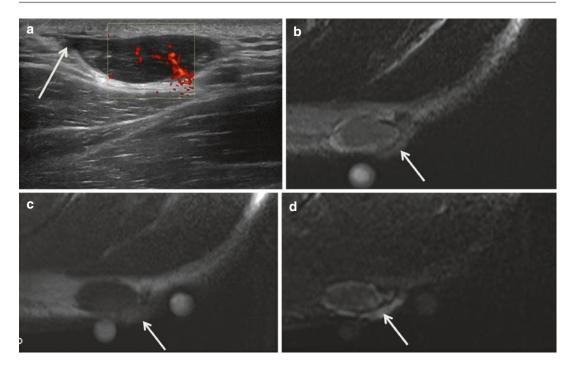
Dermatofibrosarcoma at the back left shoulder of a 44-year-old male patient. (a) US demonstration of nonhomogeneous oval mass lesion, 2.6 cm diameter, with irregular margins superficially located at the subcutaneous tissue, broad contact with the epidermis-dermis, fingerlike extension to the skin (*arrow*). Intralesional vascular structures on CDUS. (b) MRI axial T2-WI, target aspect of the lesion with peripheral higher and centrally lower SI compared to subcutaneous fat. Lateral-superficial fingerlike
